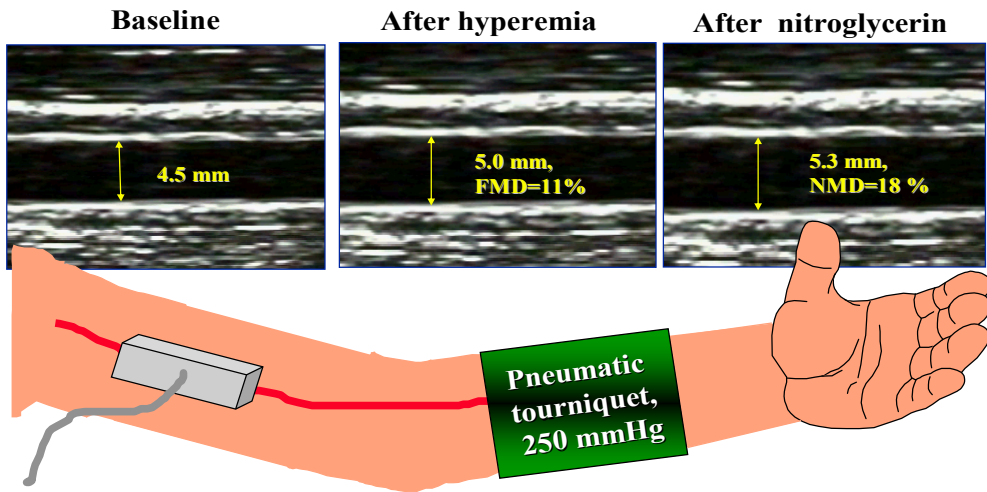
Brachial artery diameter was determined by scanning 3 times using ultrasound.
